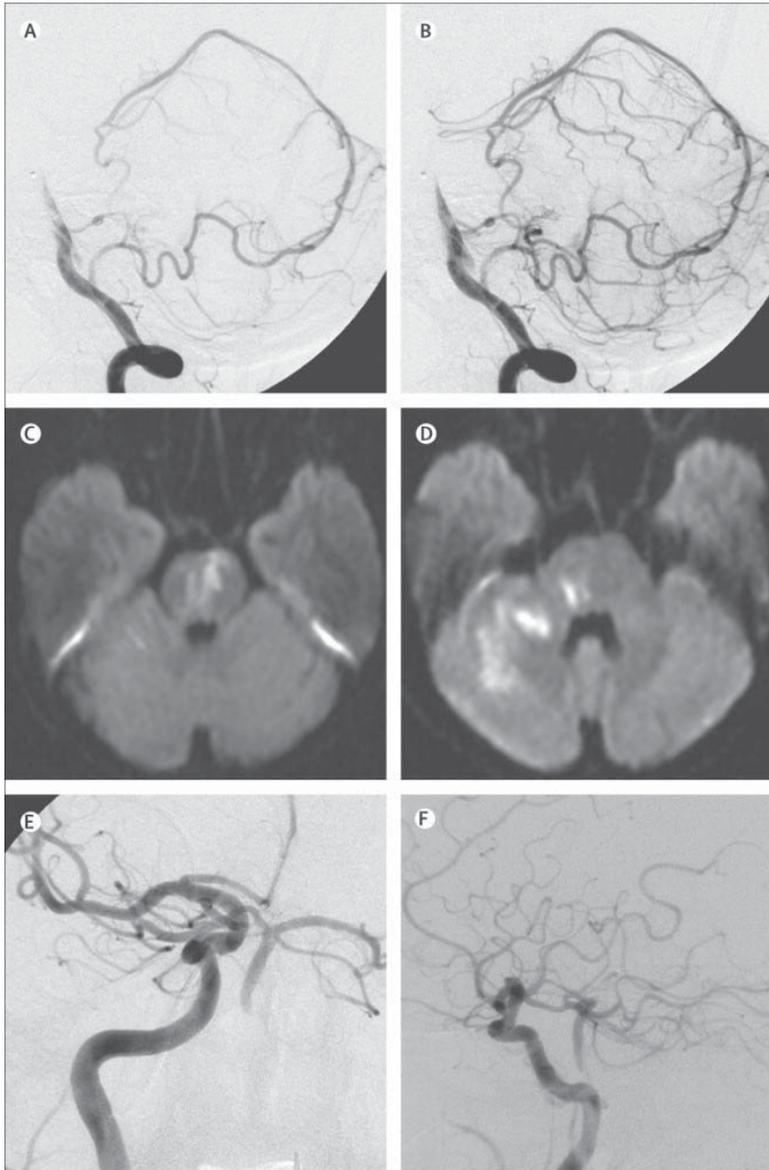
Distal and proximal basilar artery occlusions. In a 12-year-old boy with distal basilar artery occlusion, digital subtraction angiography shows good collaterals: (A) filling of the superior cerebellar artery from the posterior inferior cerebellar artery and (B) filling of the perforating arterioles in the upper brainstem. The resulting infarcts (hyperintense signal), as seen by diffusion-weighted MRI, are therefore restricted to (C) small areas in the midbrain and (D) the pons and cerebellum. (E) In a 73-year-old man with proximal basilar artery occlusion, right carotid angiography shows filling of the posterior cerebral arteries, the distal basilar artery, and the superior cerebellar arteries from the anterior cerebral circulation via the posterior communicating artery. (F) Lateral view of the patient in (E).
